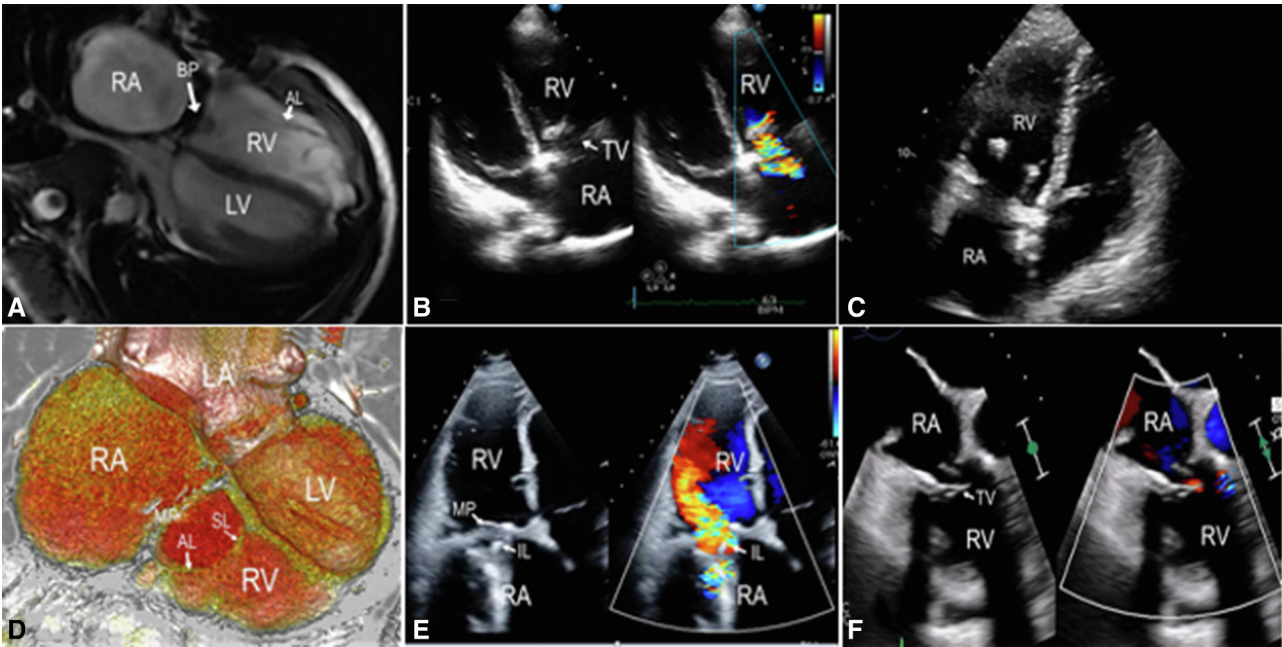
Pre- and postoperative diagnostic images of patients 1 (A-C) and 2 (D-F). A, Preoperative magnetic resonance image shows severe *right* atrial enlargement and the presence of tricuspid valve anterior and inferior leaflets tissues underneath the bioprosthesis. B, At 1 year after the repair, echocardiogram showed mild/moderate tricuspid regurgitation and mild *right* atrium and *right* ventricle dilation. C, Twelve years after the cone repair, the echocardiogram shows good tricuspid valve function and nearly normal-sized *right* heart chambers. D, Computed tomography with contrast shows a severe *right* atrial dilation and the presence of a tricuspid valve mechanical prosthesis. It reveals native tricuspid valve leaflet tissues inside the *right* ventricle. E, Prerepair transesophageal echocardiogram shows an immobile prosthetic leaflet causing severe tricuspid stenosis (mean diastolic gradient = 15 mm Hg). F, Post-cone repair transesophageal echocardiogram shows mild tricuspid valve regurgitation. RA, Right atrium; BP, biological prosthesis; AL, anterior leaflet; RV, right ventricle; LV, left ventricle; TV, tricuspid valve; LA, left atrium; MP, mechanical prosthesis; SL, septal leaflet; IL, immobile leaflet.
